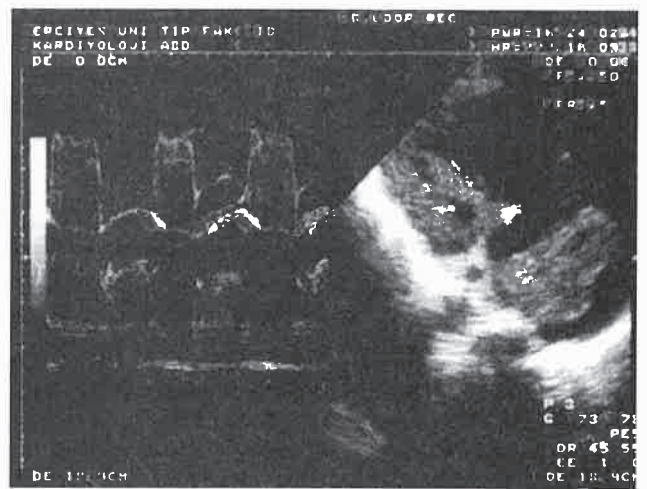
Echocardiographic view of a large right atrial myxoma during systole.
